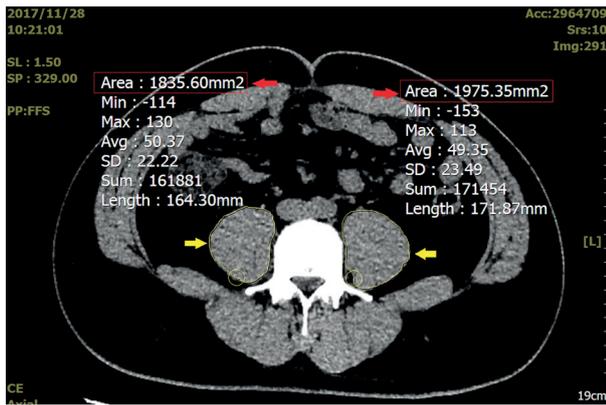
Measurement of the PMA at the CT slide of the longest transverse section of the fourth lumbar vertebra. The red arrows show the automatically calculated bilateral PMA. The yellow arrows show the clear outline of bilateral psoas muscle. Example of a 26-year-old male liver donor: PMA is 1835.60 mm² (right) + 1975.35 mm² (left) = 3810.95 mm². PMI is 1125.6mm²/m², PDI>1. *Abbreviation:* PDI, psoas muscle depletion index; PMA, psoas muscle area; PMI, psoas muscle index.
